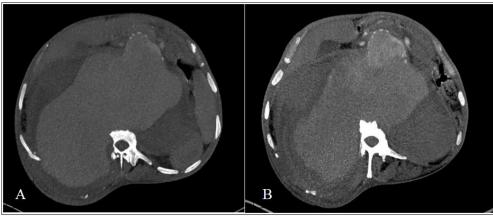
Axial images of abdominal CT, without (A) and with contrast (B arterial phase) showing a voluminous saccular aneurysm with circumferential calcifications visible in the pre-contrast images compatible with aneurysm thrombosis
